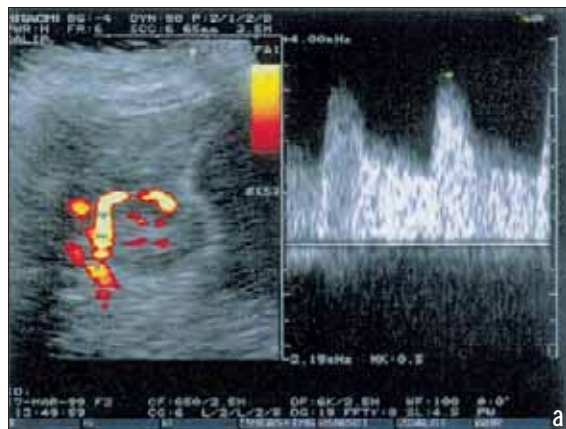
a) Power color and Doppler ultrasonography of nutritive artery around the liver node (focal nodular hyperplasia); b) Power color and Doppler ultrasonography of nutritive artery around the liver cirrhotic node; c) Doppler ultrasonography of nutritive artery around the tumor (hepatocellular carcinoma in the left liver lobe)
